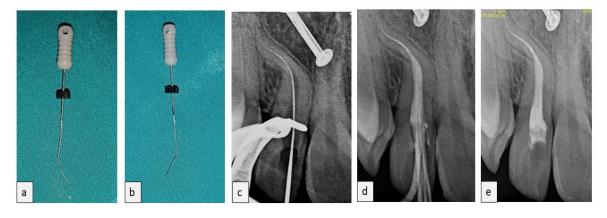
(a) and(b) Shows the degree of curvature of the root canal 21; The radiographs of (c) Working length; (d) Lateral condensation with master cone and accessory GP cones e) Obturation
